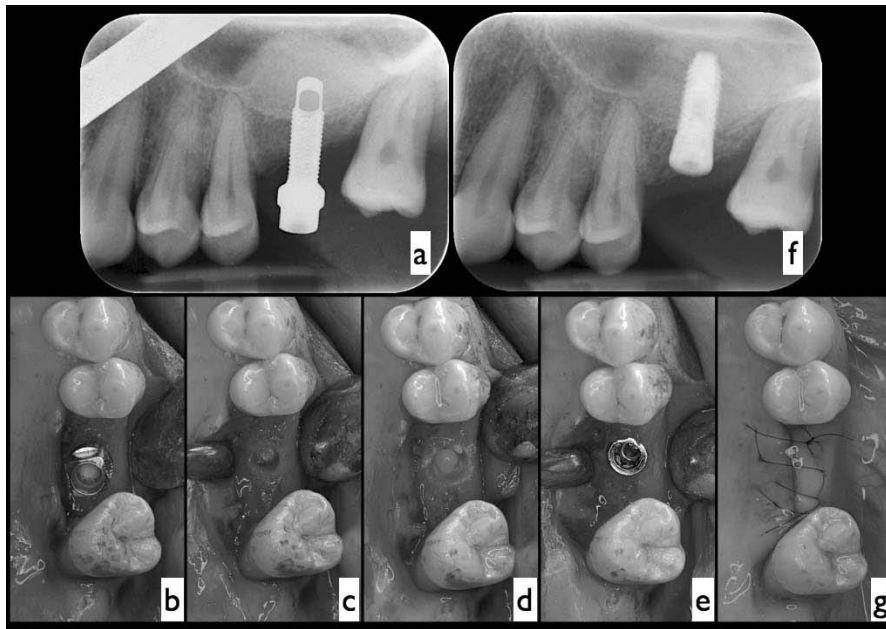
a) Intraoperative radiographic exam, after the membrane elevation procedure; b) clinical view of the ML Dispenser in place, after removing the the Hydro-mab at the end of the membrane elevation procedure; c) ML Dispenser is removed; d) the implant tunnel is enlarged; e) implant placement; f) postoperative radiographic exam; g) flap suture.*
